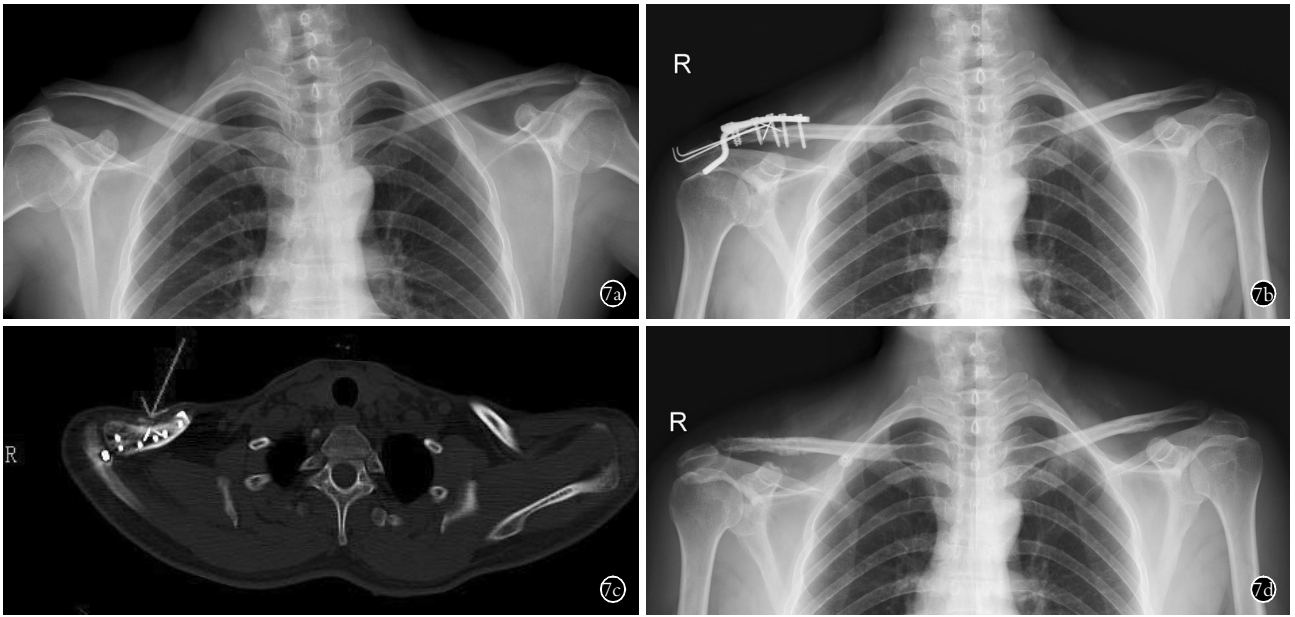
女性患者,43 岁,车祸伤致急性肩锁关节脱位 7a. 术前双侧肩锁关节正位 X 线片示右肩 V 型肩锁关节脱位(Rockwood 分类) 7b. 术后 1 个月双侧 X 线片对照显示右肩锁关节脱位复位良好 7c. 术后 7 个月复查 CT 示喙肩韧带内侧半与锁骨已经骨性愈合 7d. 末次随访时双侧肩锁关节 X 线片对照显示右侧喙锁间隙已恢复正常
